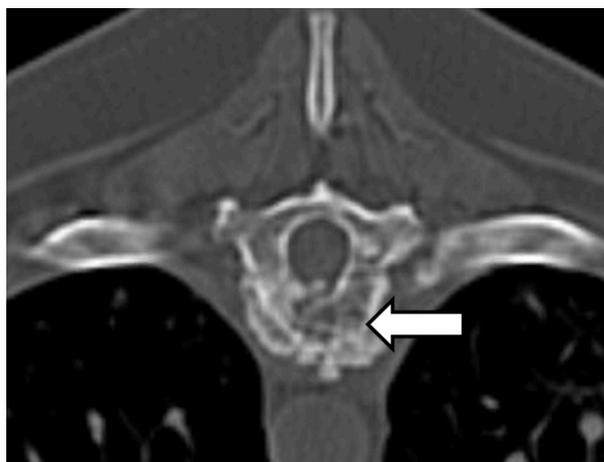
Transverse plane CT image of the osteolytic and proliferative lesion (white arrow) in the ninth thoracic vertebrae caused by an invasive IFI.
